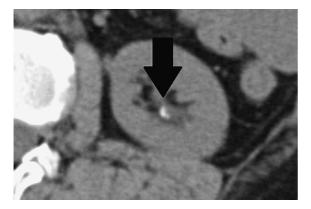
Preoperative CT of the donor, demonstrating the 3-mm left renal calculus (*arrows*).
